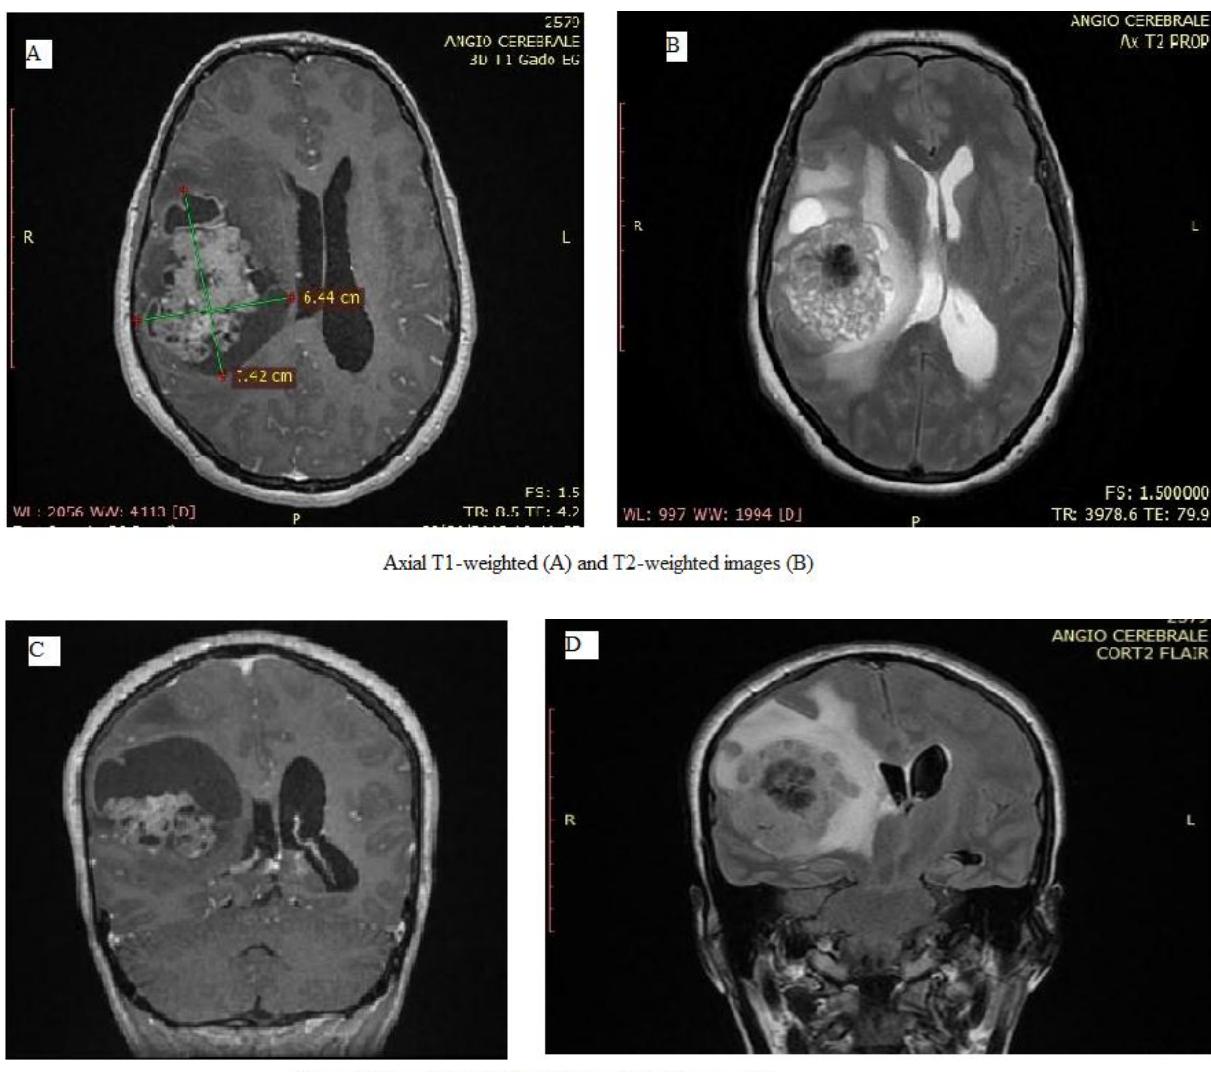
MRI-angiography.
